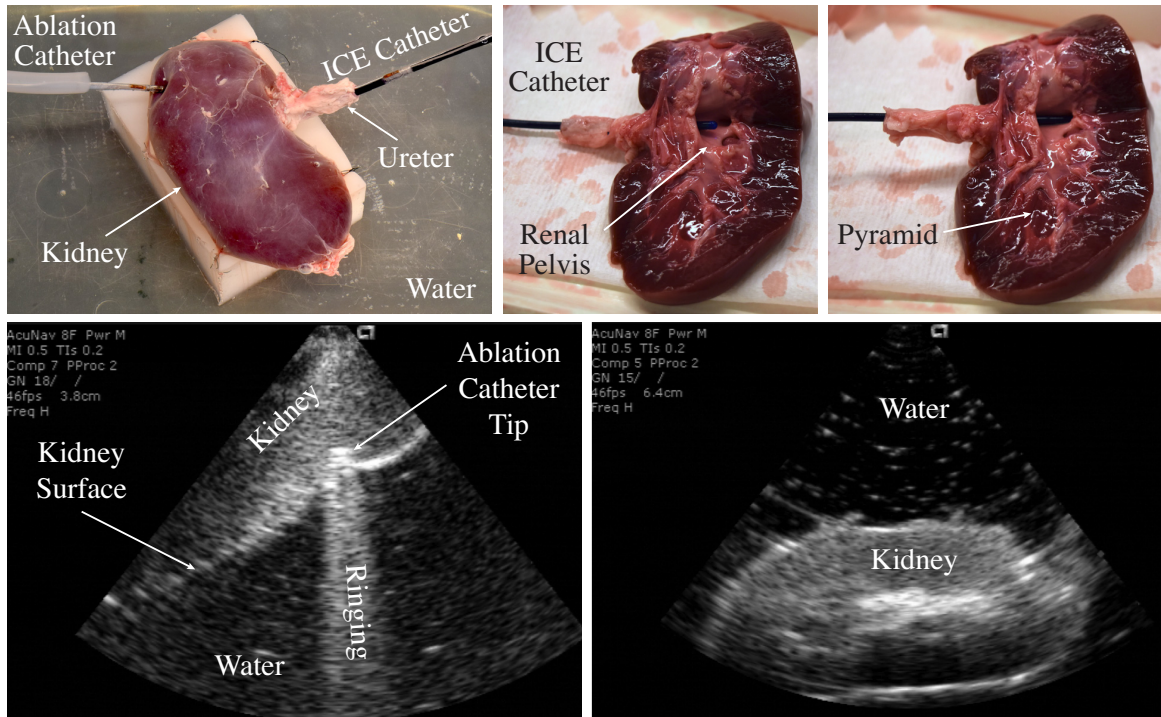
Ex vivo* ultrasound study of a kidney.
